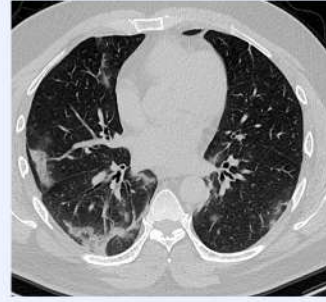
Axial HRCT of the chest at the level of the base of the lung parenchyma shows patches of peribronchovascular consolidation in bilateral lung parenchyma – a pattern usually seen in the peak stage of COVID -19.
